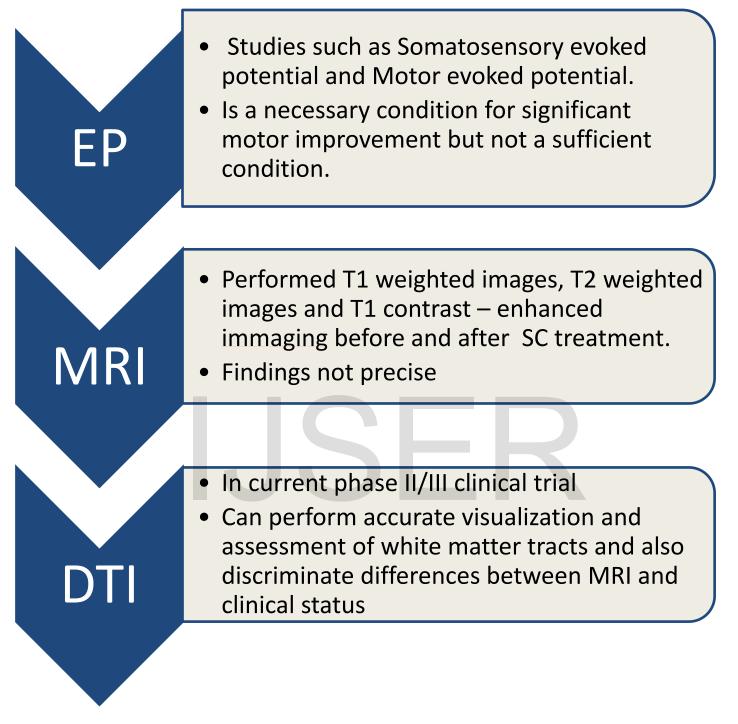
The table classifies the different diagnostic studies for epilepsy like Electrophysiological (EP) Studies, Magnetic Resonance Imaging(MRI), And Diffusion Tension Imaging (DTI).
